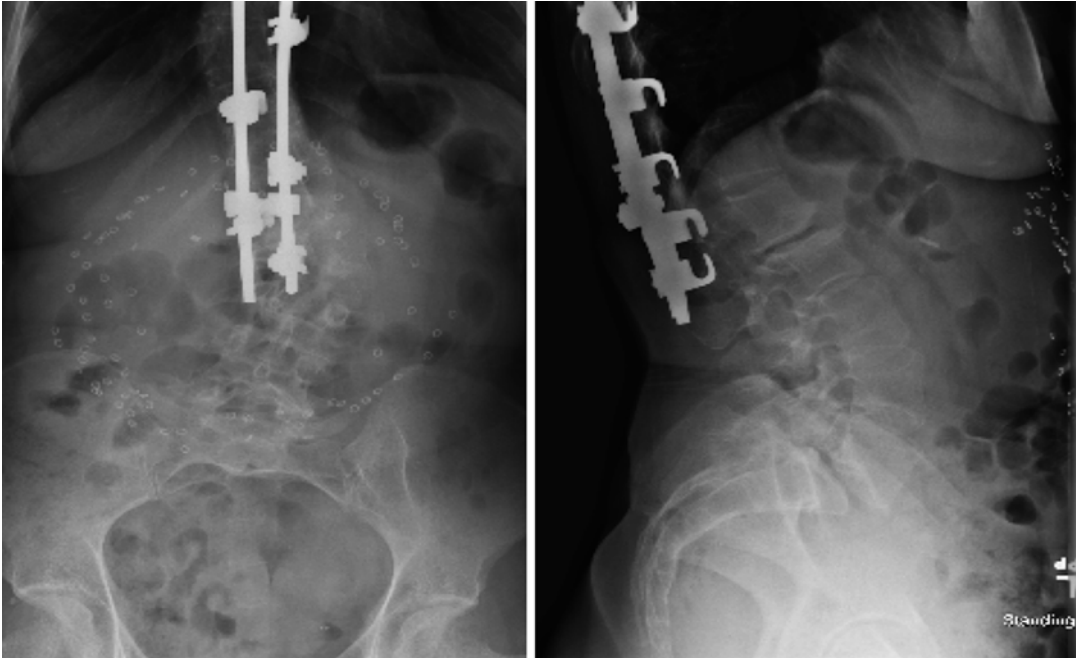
Anteroposterior (AP) and lateral standing radiographs demonstrating spondylolisthesis of L5 on S1 with long fusion segment above
